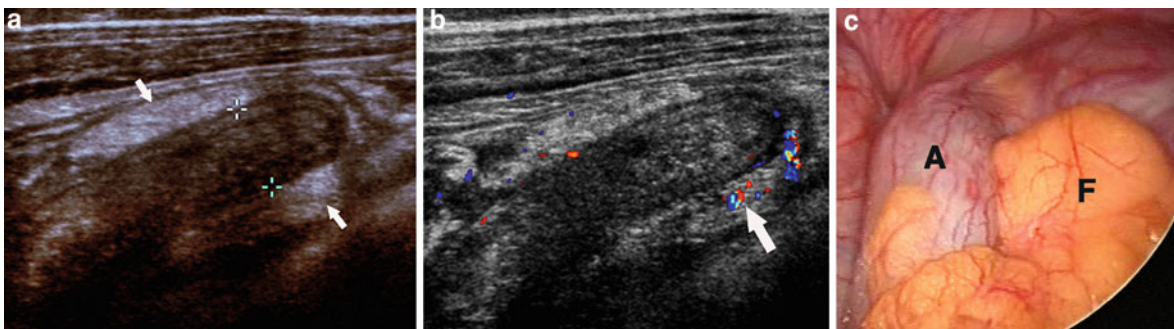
a, b, c Early acute appendicitis with echogenic periappendiceal fat within mesoappendix. In a, grayscale graded-compression sonogram of long axis of appendix, notice dilated appendix (calipers). In addition, there is echogenic fat within mesoappendix
